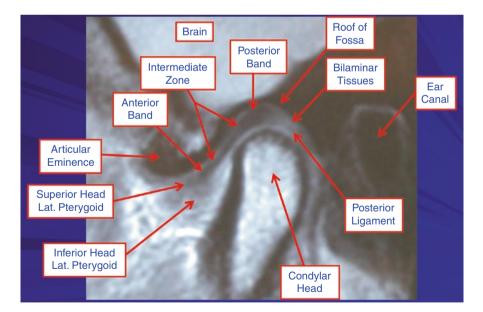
MRI of a normal TMJ in closed position with disc in position. The anatomical landmarks are labeled
